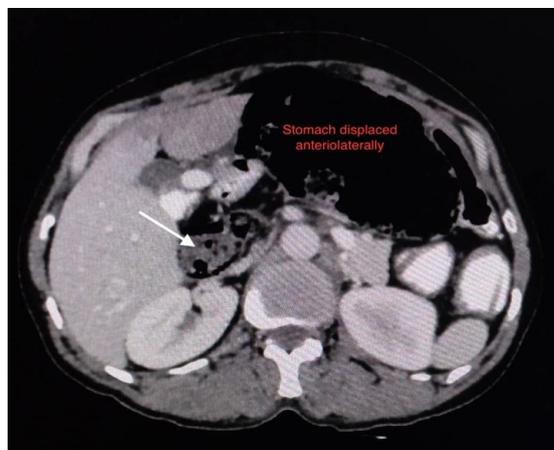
Axial Section of CECT (Contrast Enhanced Computed Tomography) Showing Dilated Foramen of Winslow
